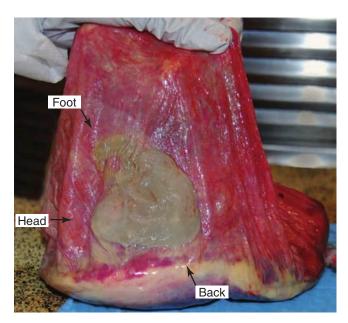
This fetus papyraceus is a tan ovoid mass compressed against the fetal membranes. Anatomical parts can be identified as marked. Demise of this twin had been noted during sonographic examination performed at 17 weeks' gestation. Its viable co-twin delivered at 40 weeks. (Reproduced with permission from Dr. Michael V. Zaretsky.)
